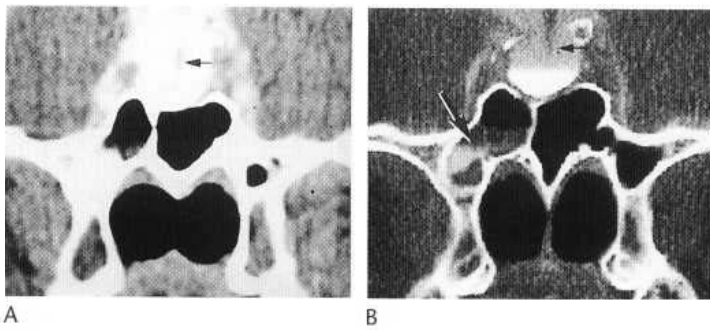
CSF fistula. CT cisternography. Direct coronal sections with patient prone. Soft tissue (A) and bone (B) window. Contrast medium has entered an empty sella. Pituitary stalk is arrowed. Bone window shows level of contrast fluid in the sphenoid sinus on the left.
